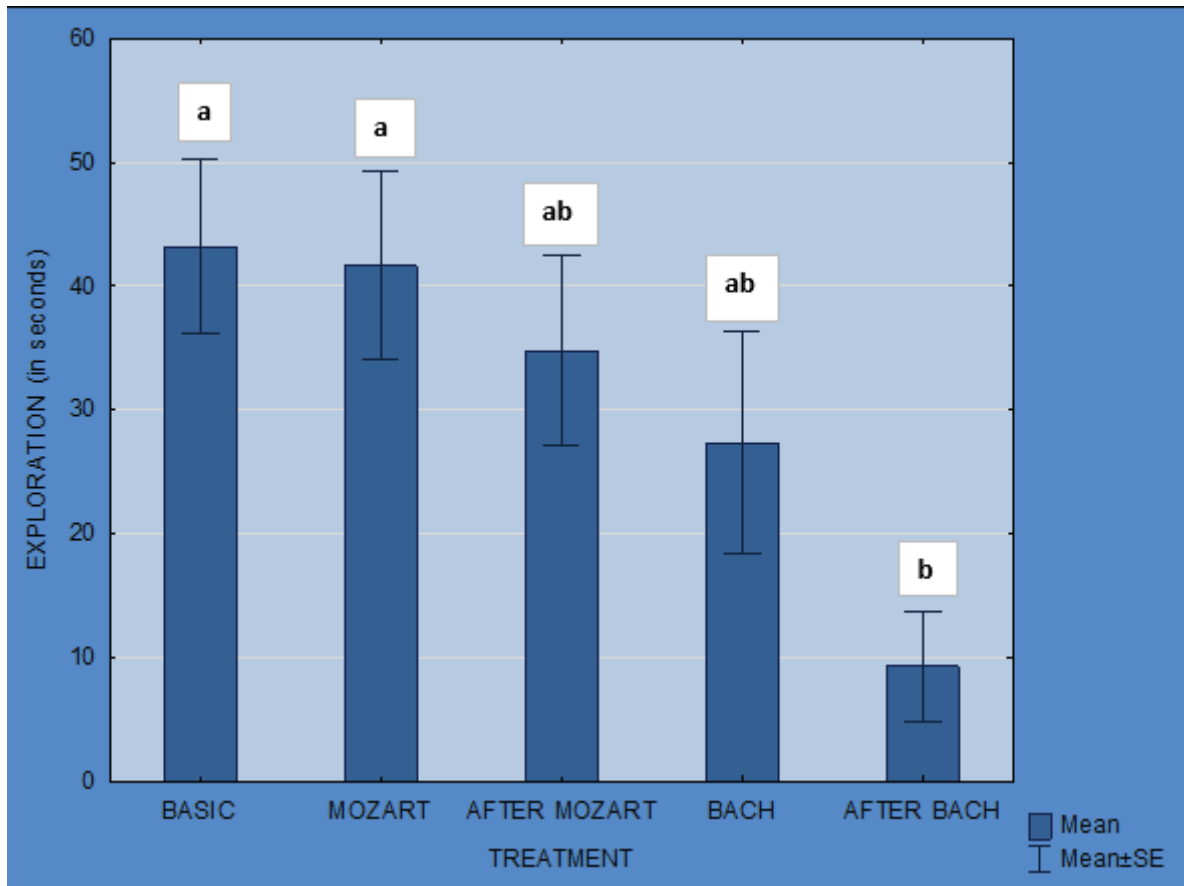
Means and Standard Errors of exploration of the ultrasound recording device behaviour, in seconds values having different upper case letter are significantly different.
